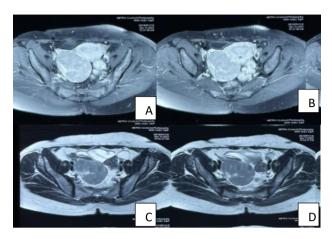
(A-D): Axial image of MRI.
